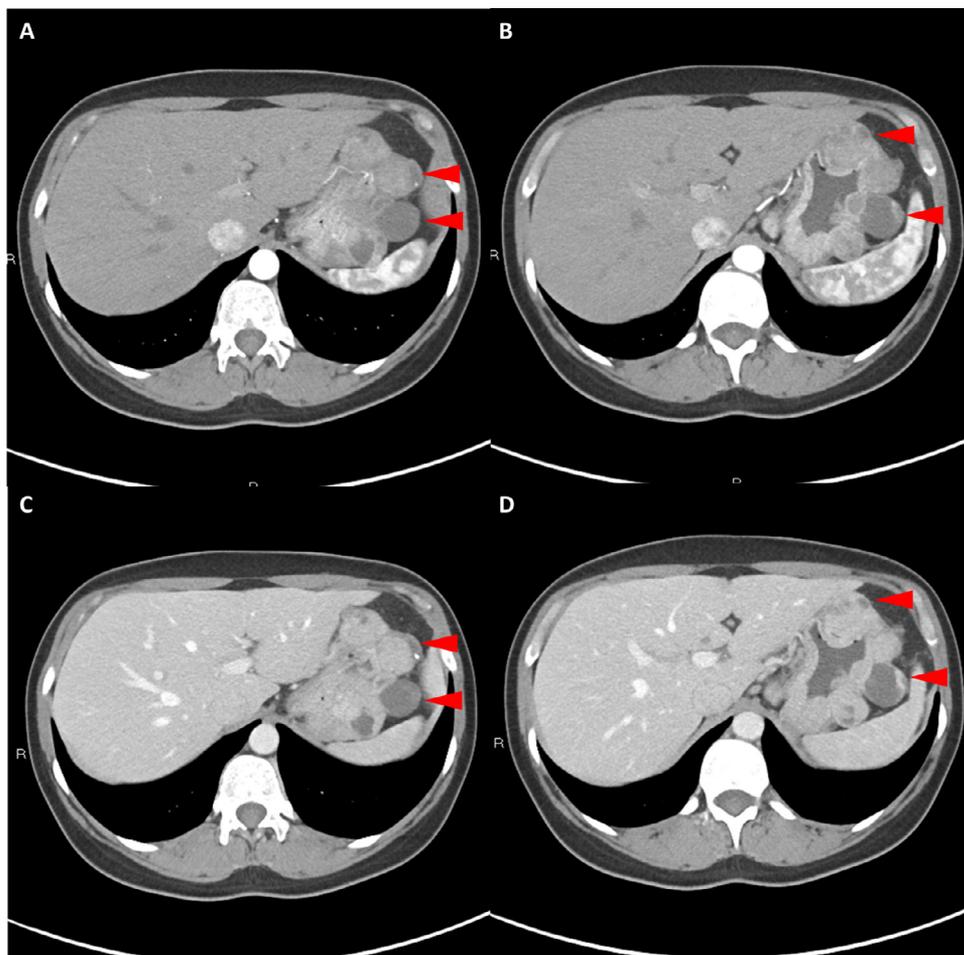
Axial CT images of multiple gastrointestinal stromal tumors. (A and B) Axial arterial phase contrast-enhanced CT images and (C and D) Axial venous phase contrast-enhanced CT images demonstrate multiple rounded, heterogenous, enhancing masses with solid and cystic components. The masses are submucosal in location and exophytic in configuration.
